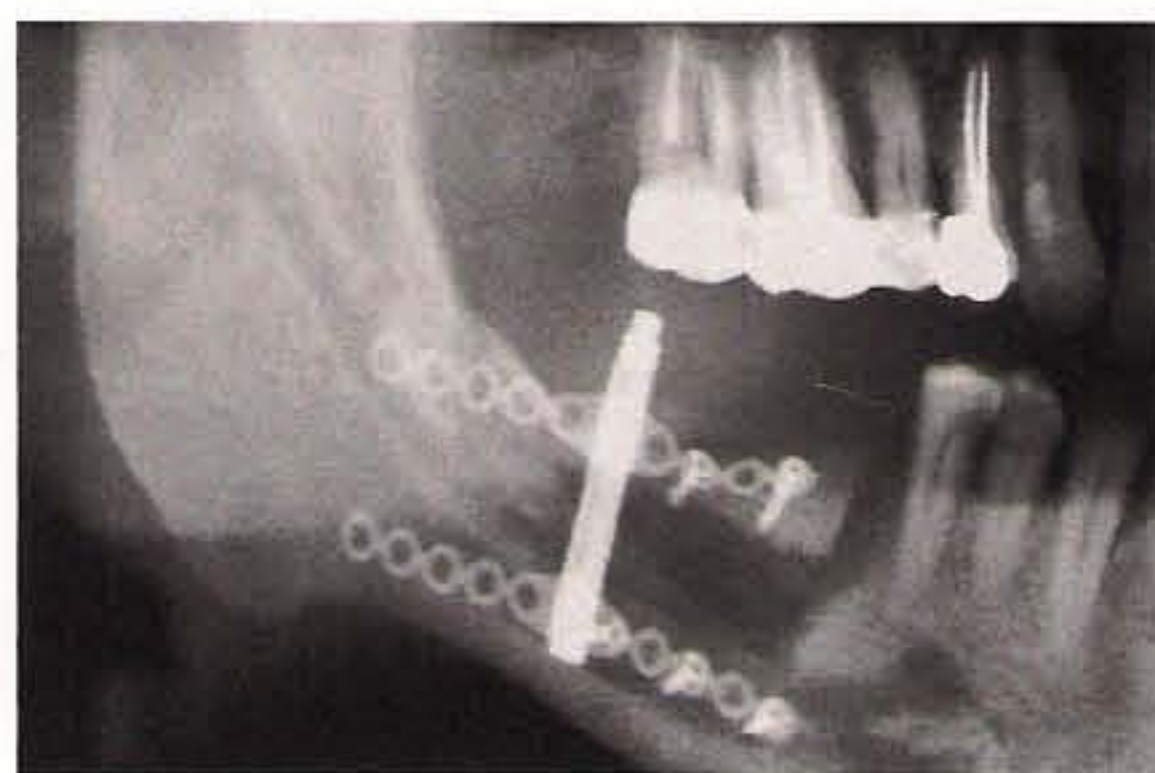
A panoramic radiograph is taken at the completion of the distraction to assess the space created by the osseous distraction and the recovered vertical dimension of the alveolar crest.
